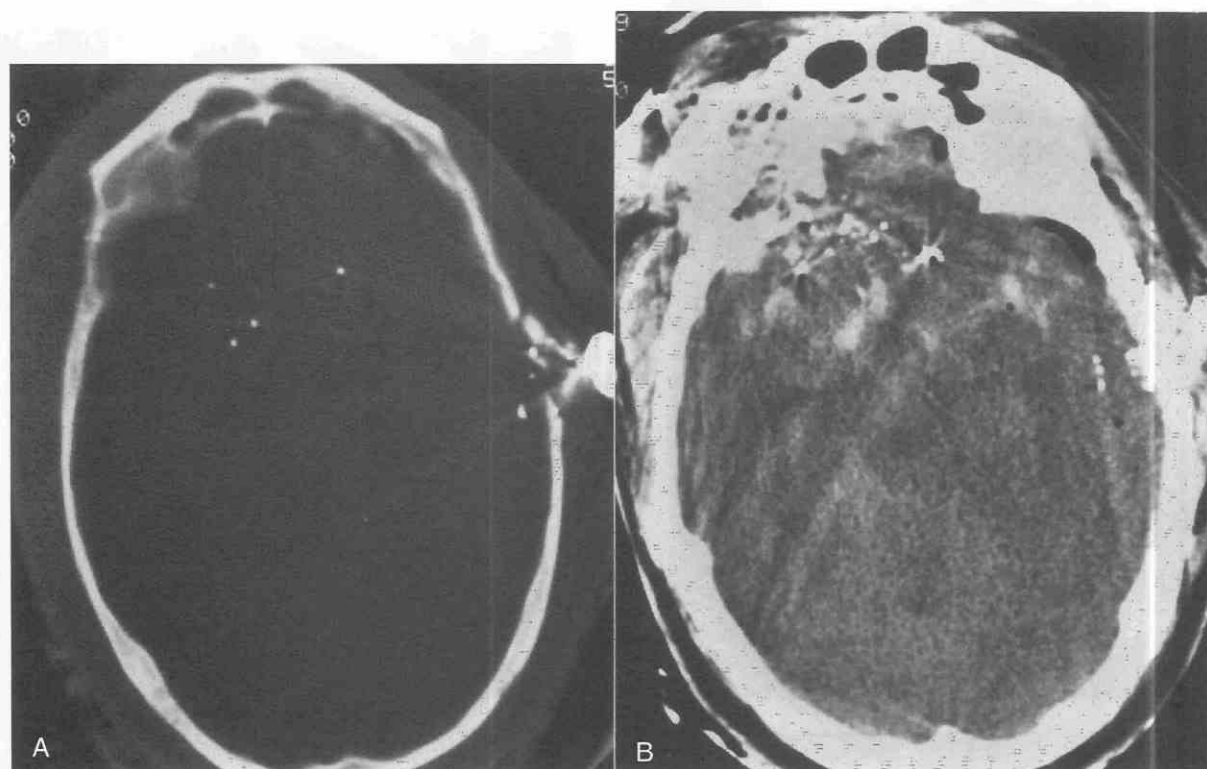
A, Axial CT scans with bone window setting demonstrates missile adjacent to the left temporal bone, temporal bone fracture, and missile-fragments in brain parenchyma. B, Brain window setting reveals multiple hemorrhagic-foci in the frontal and temporal lobes, effacement of the basal cisterns, and pneumocephalus.
